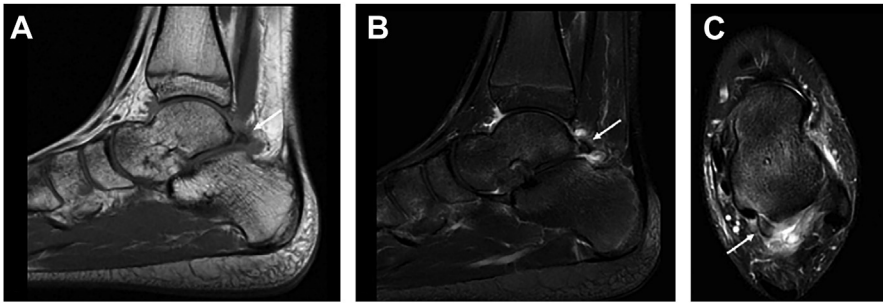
Posterior impingement of the ankle. T1W (A) and T2W fat saturation (B, C) MR images of a 13-year-old boy depicting bone marrow edema on a nonfused SOC of the lateral tuberosity of the posterior process of the talus, with small articular effusion, reactionary synovitis and Kager fat pad edema (arrows).
